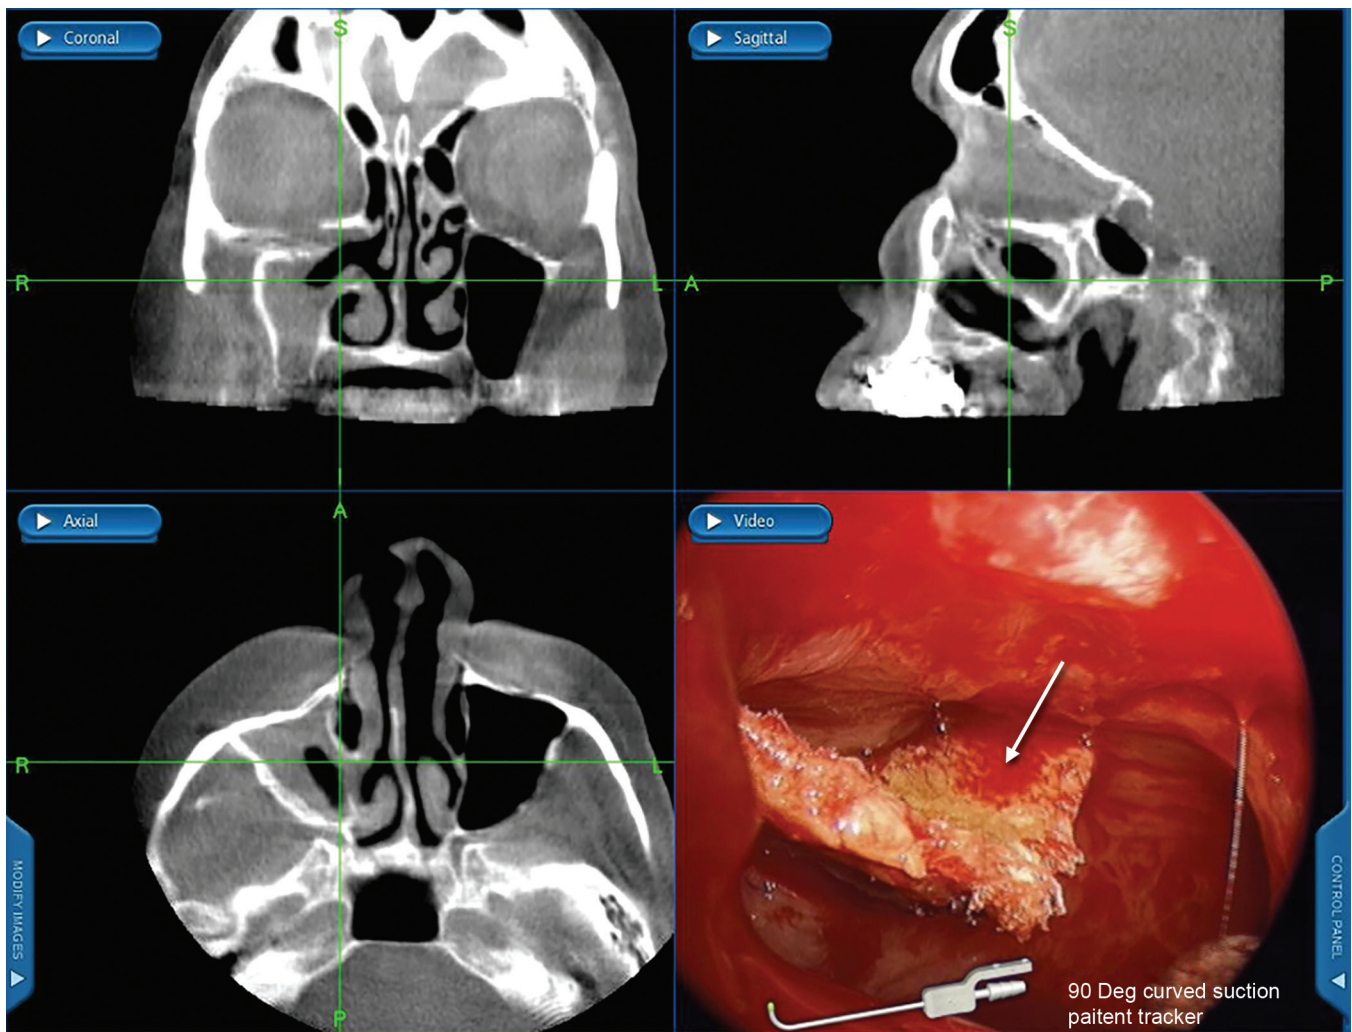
Retained maxillary sinus foreign body. Computed tomography and endoscopic images demonstrate an infection of the right maxillary sinus associated with a piece of Gore-Tex originating from a prior orbital floor reconstruction (arrow).
